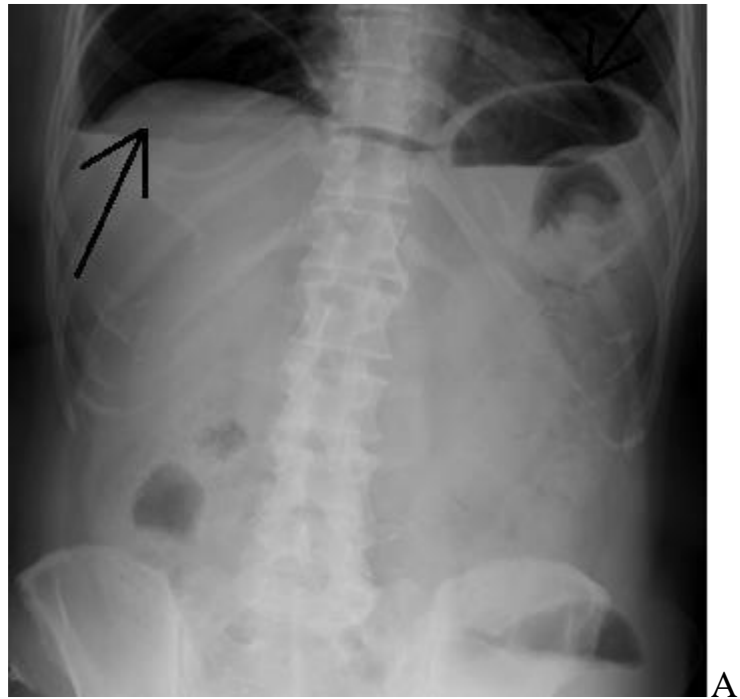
Overview direct X-ray of the abdominal cavity (A – vertical position). Free gas under the dome of the diaphragm (arrows) is a sign of closed damage to the hollow organ (B)
